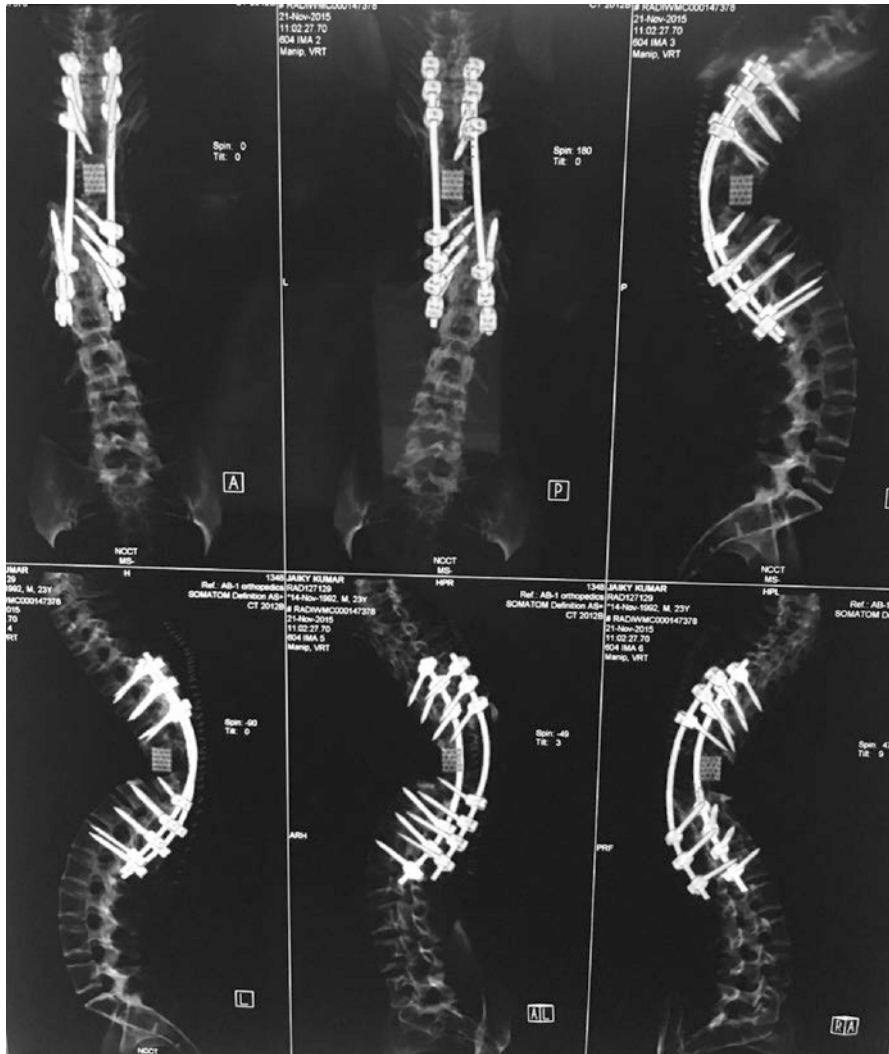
Post-operative CT scan following vertebral column resection and deformity correction
